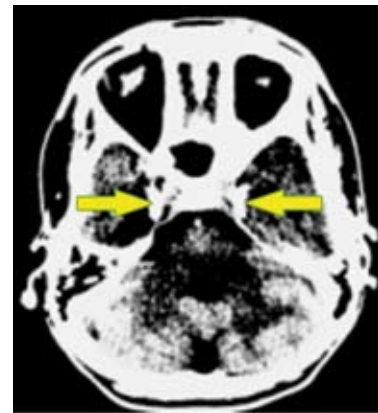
Plain CT scan reveals the pathognomonic bean shaped calcifications in the parasellar areas of the brain (Case 2).
